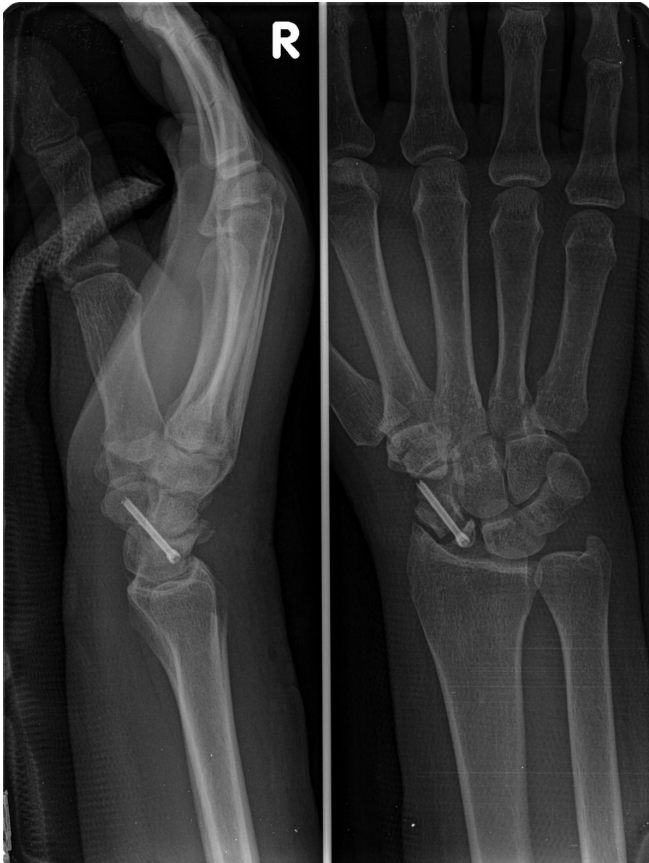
Postoperative early X-ray image. H.D, 35 year-old.
